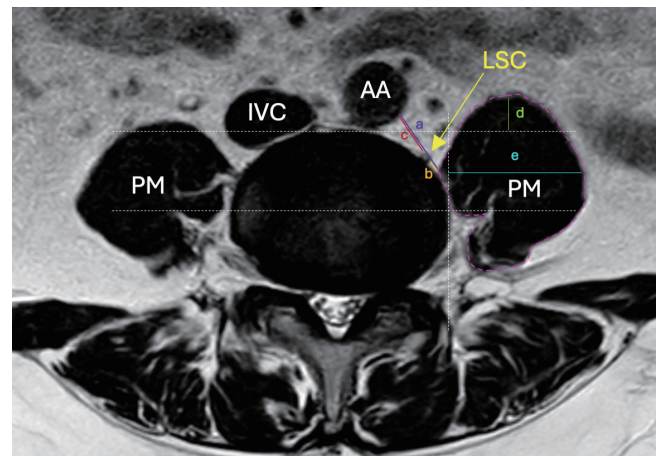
T2-weighted image at the L4–5 disc level in axial view. (a) The distance from the lateral border of the abdominal aorta to the anteromedial border of the left psoas muscle (AA-PM), the surgical corridor. (b) The distance from the lateral border of the left LSC to the anteromedial border of the left psoas muscle (LSC-PM). (c) The distance from the medial border of the left LSC to the lateral border of the abdominal aorta (LSC-AA). (d) The distance from the anterior border of the vertebral body to the anterior border of the left psoas muscle. (e) The distance from the lateral border of the vertebral body to the lateral border of the left psoas muscle. Yellow arrow showing the left LSC. Pink dashed line showing the cross-sectional area of the left psoas muscle. PM, psoas major muscle; IVC, inferior vena cava; AA, abdominal aorta; LSC, lumbar sympathetic chain.
